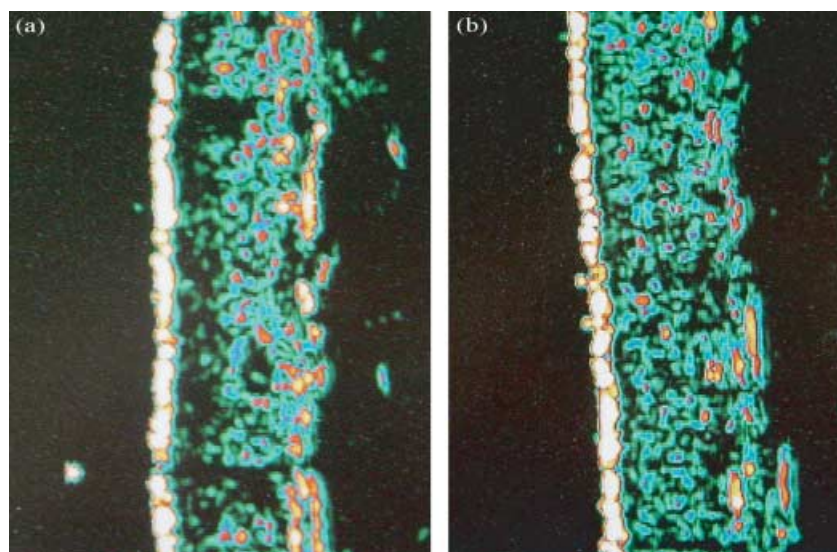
Cross-sectional ultrasound images, back of hand. A 43-year-old subject, active group. At study entry (a), and 3 months (b). A progressive replenishment of low echogenic, dark areas is seen over time.
